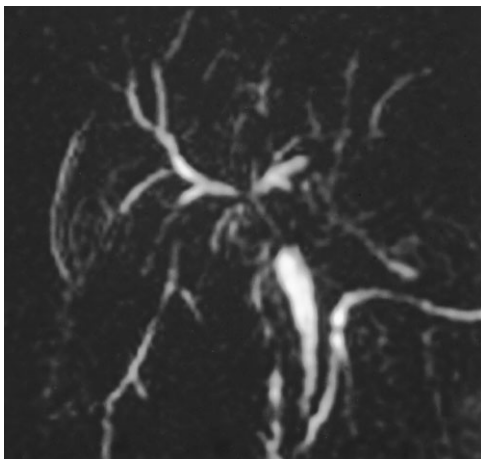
Floxuridine-induced cholangitis in a 64-year-old woman with jaundice who was treated with intra-arterial floxuridine for metastatic colon cancer. Coronal MR cholangiopancreatography image shows common hepatic duct and hilar strictures with proximal ductal dilatation. (Copyright Vitellas et al. Radiographics 2000;20:959-975.)
